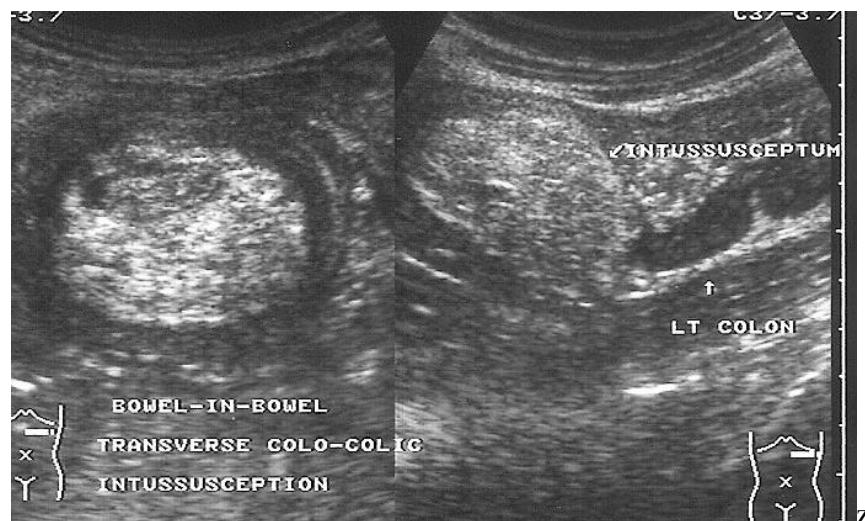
Sonogram showing bowel-in-bowel appearance of a transverse colo-colic Intussusception
